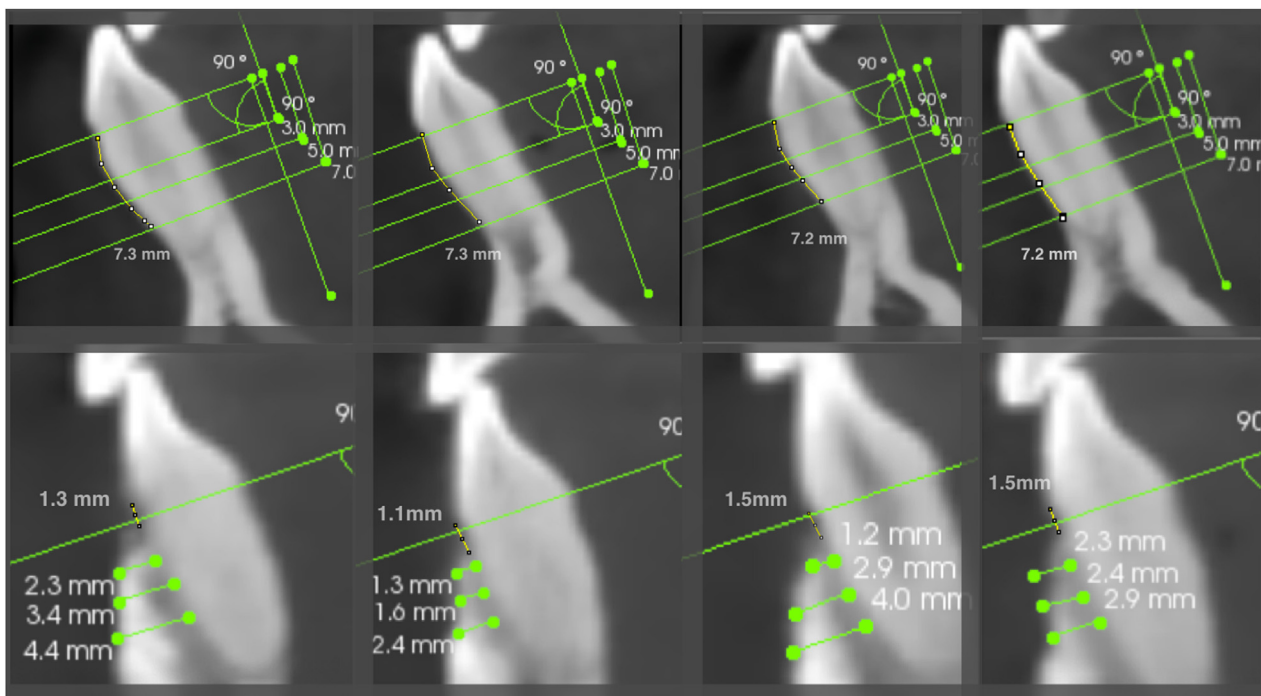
Pre- and post-operative measurements on CBCT sections. Distance from Cemento-Enamel Junction (CEJ) to Marginal Bone Level (BML) were compared. See Table 2 for Results.
